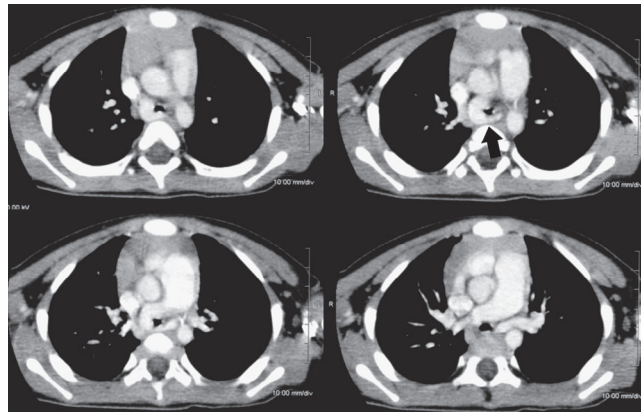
■ Pulmonary sling (aberrant left pulmonary artery). Four contiguous enhanced computed tomography images at the level of the aortopulmonary window show that the left pulmonary artery (arrow) arises from the right pulmonary artery. (Courtesy Koji Takahashi, MD, Asahikawa Medical College, Asahikawa, Japan.)
